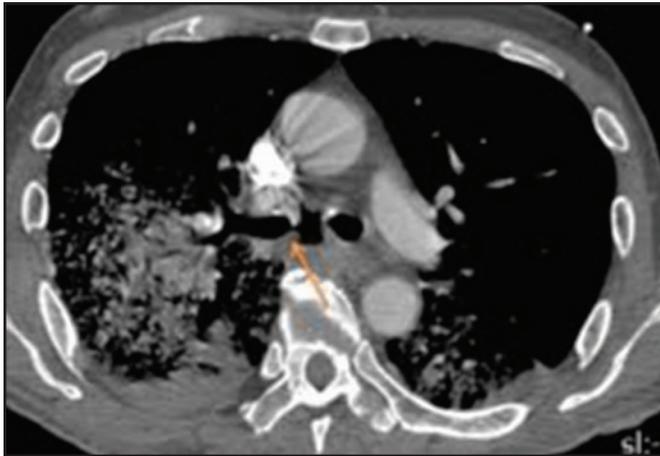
Axial computed tomography scan: mediastinal window visualization shows a fistulous tract of the right main bronchus (arrow). Partially visualized bilateral consolidations, mainly in the right hemithorax.
